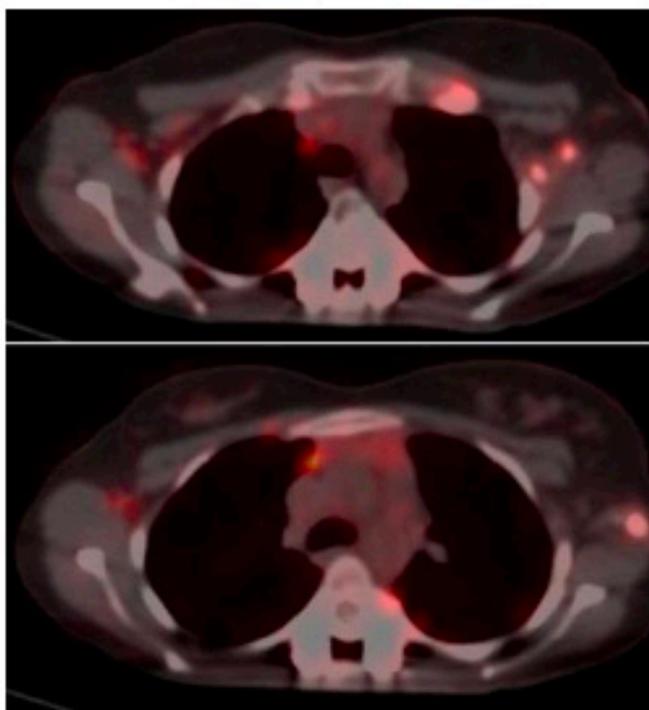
Recurrence at left axilla and left 1st costochondral junction in PET-CT.
